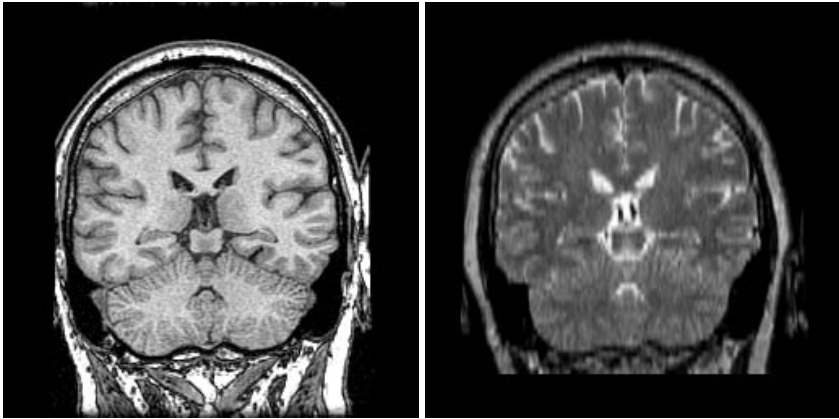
2D MRI images used for testing, T1 (left) and T2 (right)
